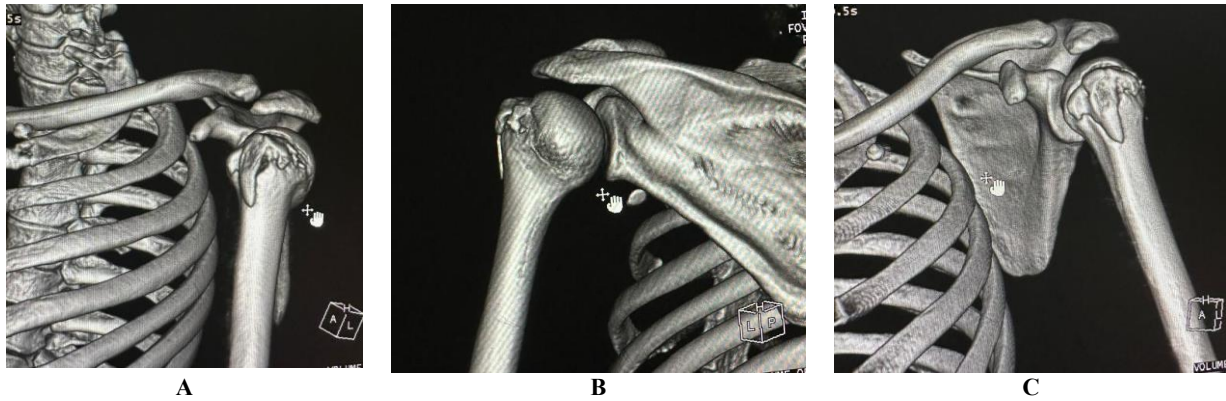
Three-dimensional CT reconstructions obtained after reduction in three views, showing a reduced glenohumeral joint and a displaced greater tuberosity fracture
